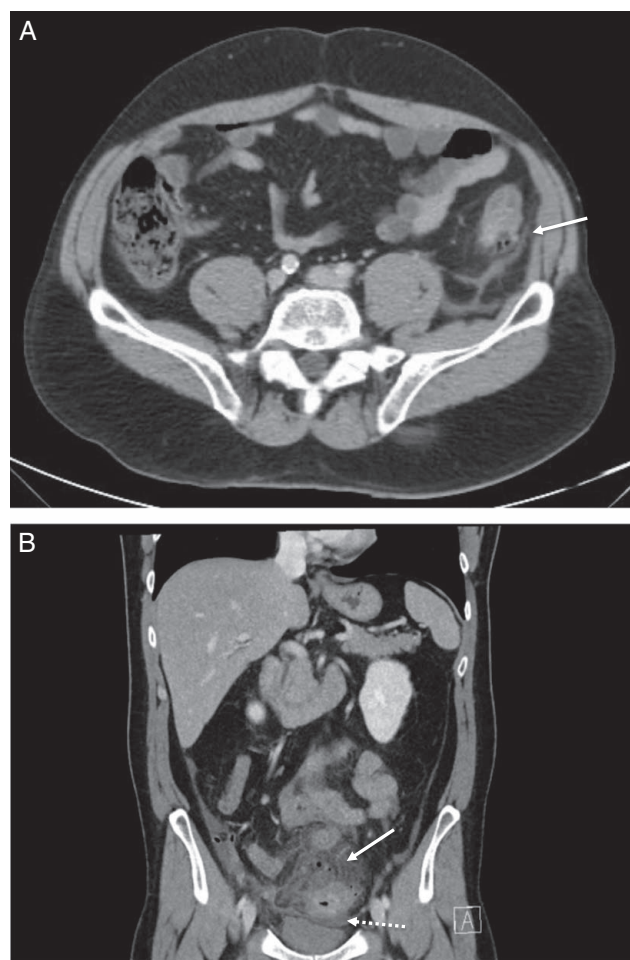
Computed tomography scan at index admission. (a) Patient presenting with only pericolic free gas (arrow). (b) Patient presenting with pericolic free gas (arrow) and pericolic fluid (dotted arrow).
